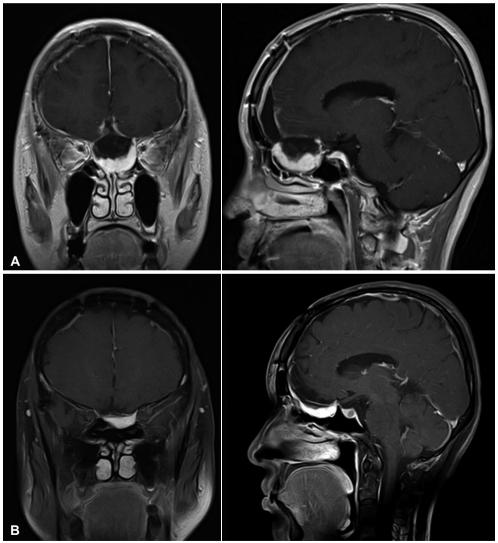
MRIs after one day and five years postoperatively. A: Postoperative MRIs with gadolinium at postoperative a day show a remnant mass at the thinned skull base. B: MRIs with gadolinium after five years reveal no tumor growth and widening of nasal cavity. The tumor is well controlled. MRI, magnetic resonance imaging.
